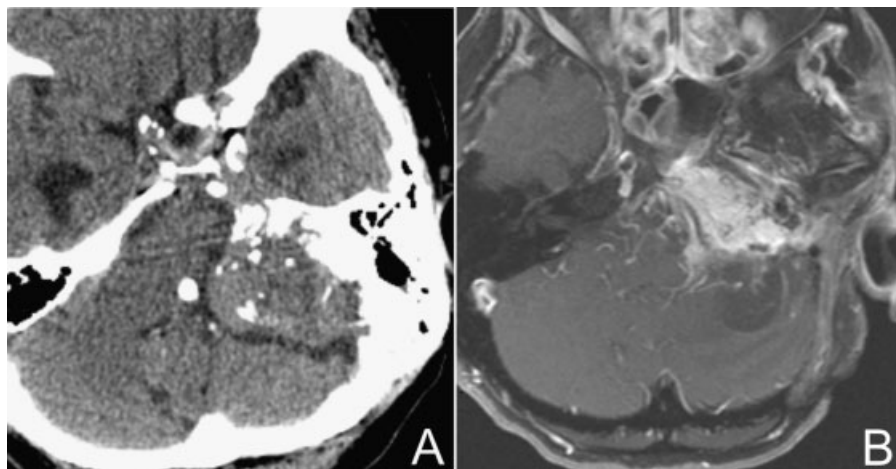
(A) Axial computed tomography image demonstrating a large (5.5 cm maximum diameter) left-sided skull destructive skull base lesion extending from the posterior fossa to the left lateral clivus. (B) One year postoperative axial magnetic resonance imaging with gadolinium demonstrating subtotal resection with posterior fossa decompression and residual disease along the petrous apex and clivus.
